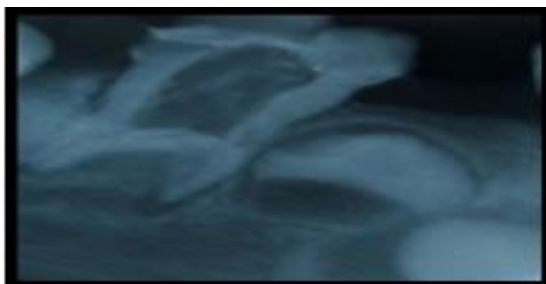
Intra oral radiograph revealed taurodontics 85 and missing 45
